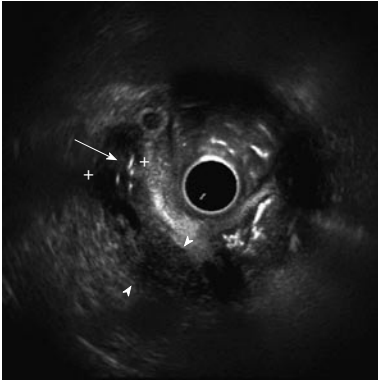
Endoscopic ultrasound image of the same patient as in Figure 2, showing dilated common bile duct measuring 11.8 mm with stent *in situ* (arrow); a mass is seen in the periampullary region measuring 1.2 cm × 1.8 cm (arrowheads).
